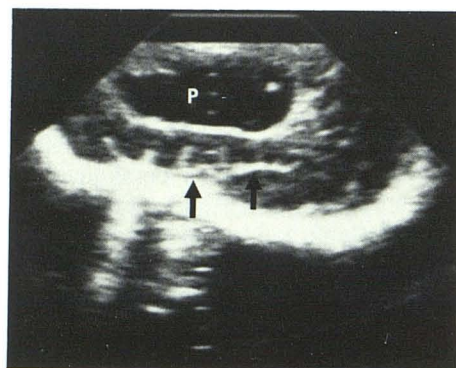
Mature porencephalic cyst (P) at 5 weeks of age. Steeply angled parasagittal sonogram. Depression of Sylvian fissure (arrows).
